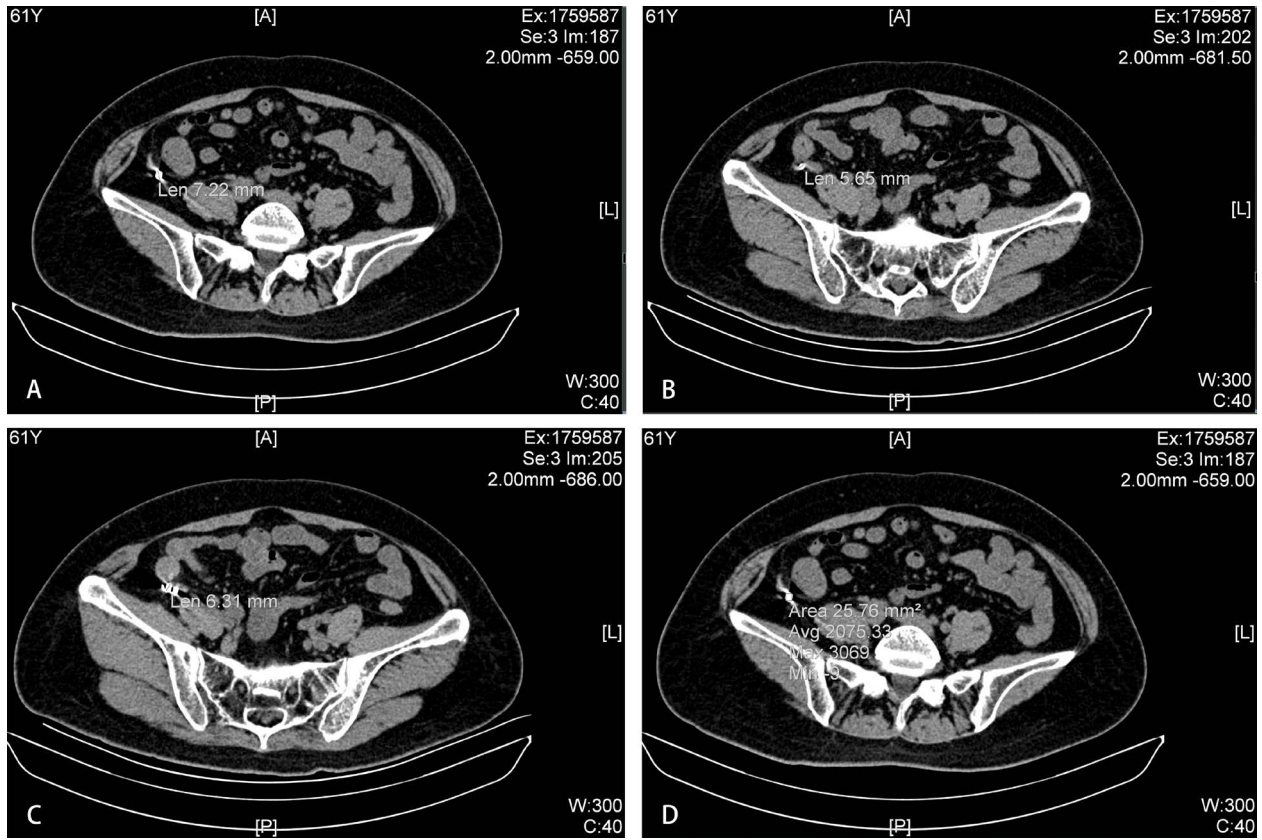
The preoperative CT scan revealed the presence of four metal-density objects within the appendix cavity of approximately (A 7.22mm, B 5.65mm, C 6.31mm and D 5.00mm in diameter with CT values between 2000-3000 Hu).
